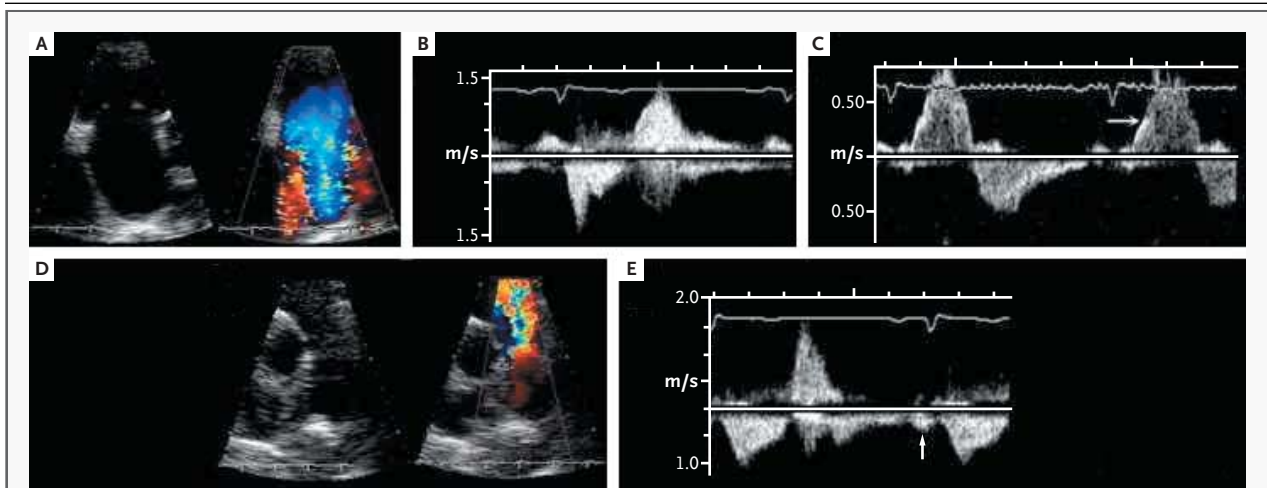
Typical Echocardiographic Appearance of Advanced Carcinoid Heart Disease.
